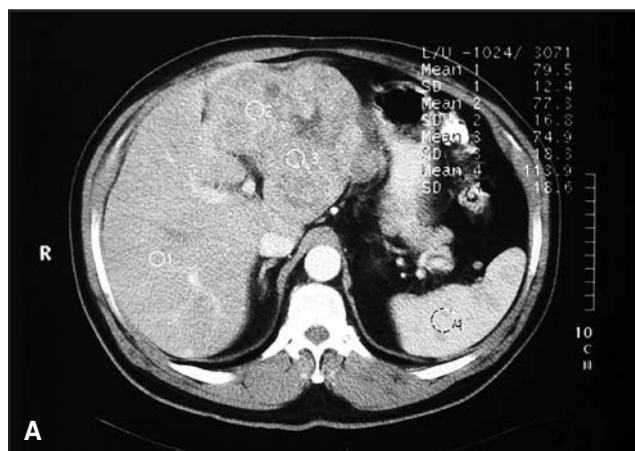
(A) 10-cm tumor in left hepatic lobe prior to TACE. (B) Contrast CT scan 3 months after TACE showing marked necrosis of tumor.
